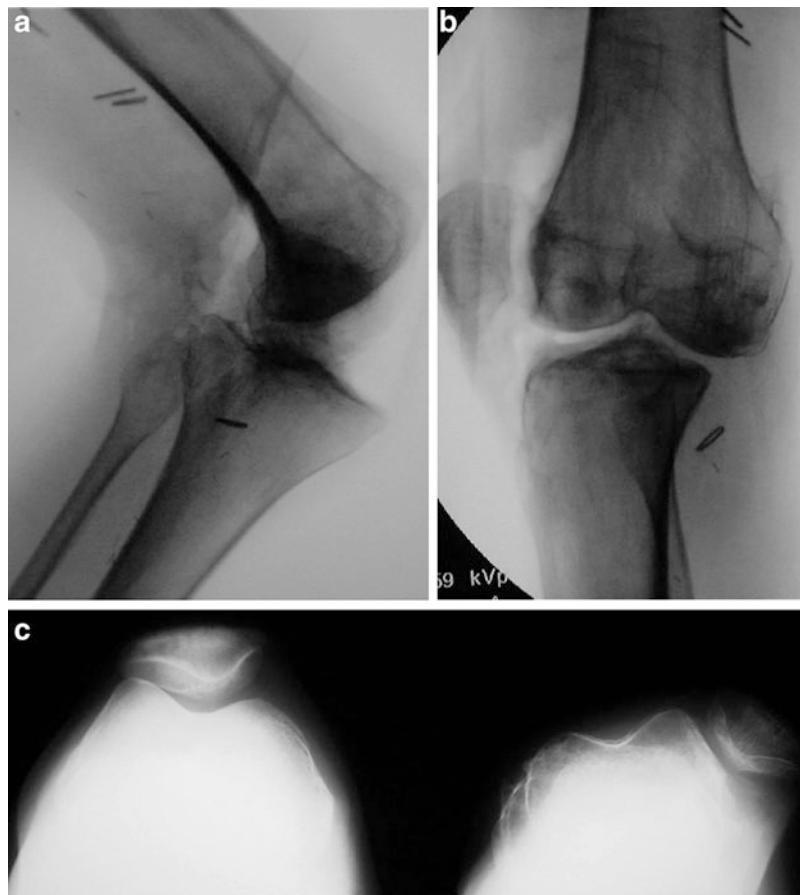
Preoperative (a) anteroposterior (AP) and (b) lateral radiographs of the left knee demonstrating rotatory knee dislocation with the tibia externally rotated approximately 70° in relation to the femur. (c) Merchant views demonstrate lateral patellar dislocation on the left side
